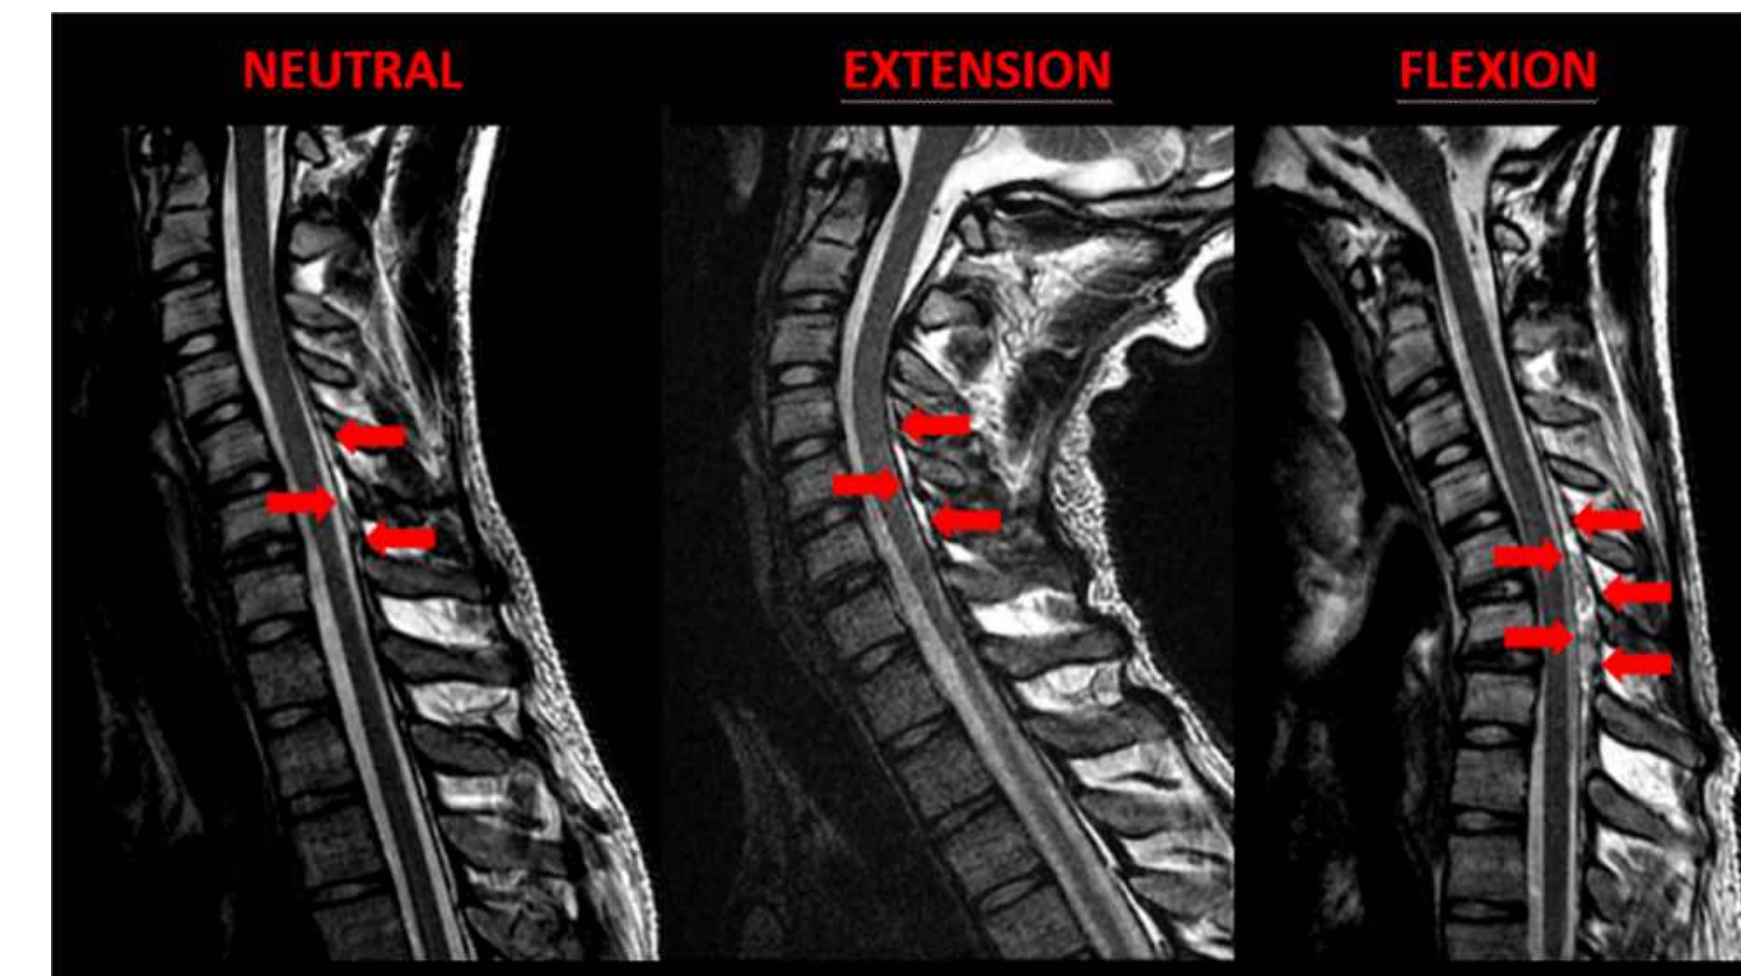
The 3 positions of the functional MRI in a T2 sagittal cut. It is observed that in the neutral position and in extension the alteration that is revealed is slight, while in flexion the anterior migration of the dura mater and the increase in the posterior epidural space can be clearly observed.
